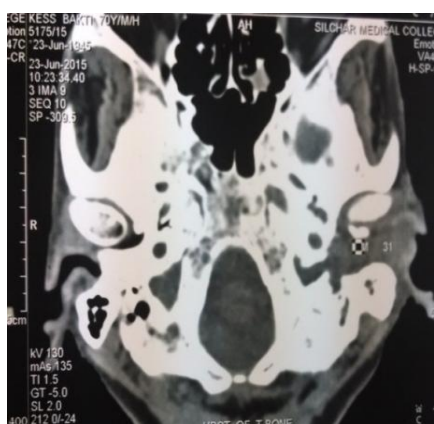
Shows an axial slice of HRCT scan of Temporal bone of the concerned patient with the above mentioned findings.
